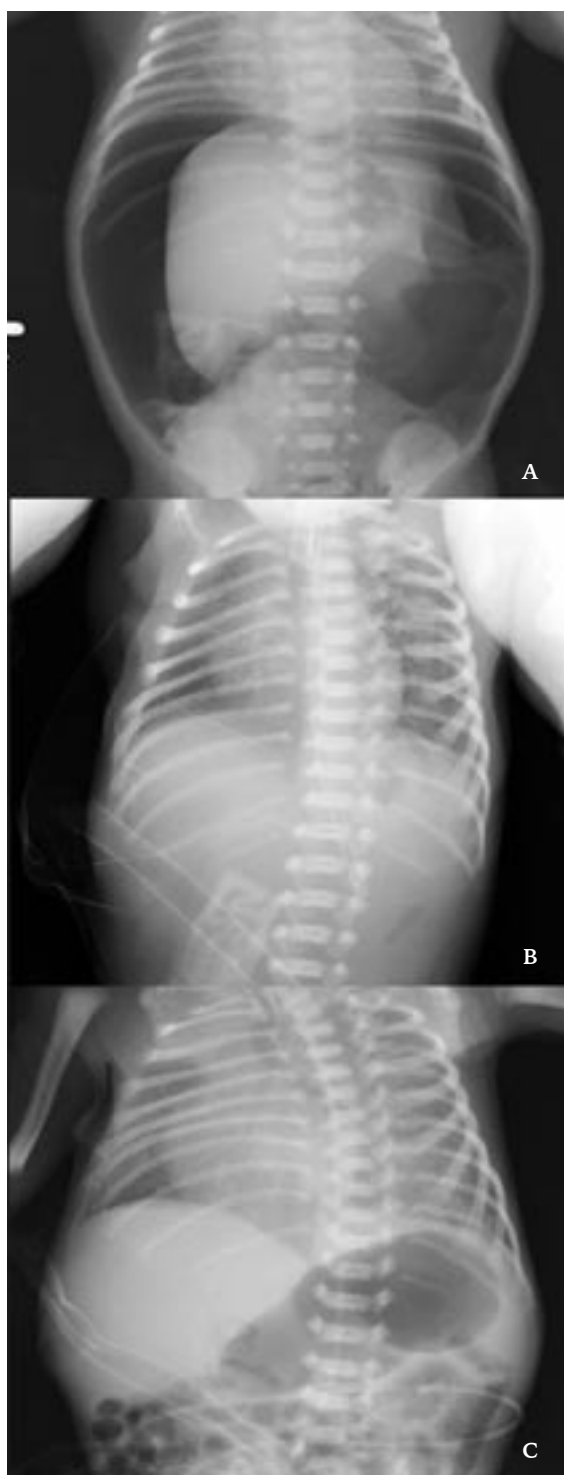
Abdominal radiographs of the patient. A) note the excessive amount of free air in the peritoneal cavity (massive pneumoperitoneum) with a small stomach shadow; B) note the lower tip of the orogastric/nasogastric catheter and absence of gas shadows in the abdomen following insertion of the drain; C) complete resolution of the free air with presence of gastric gas shadow on follow-up abdominal radiograph.
